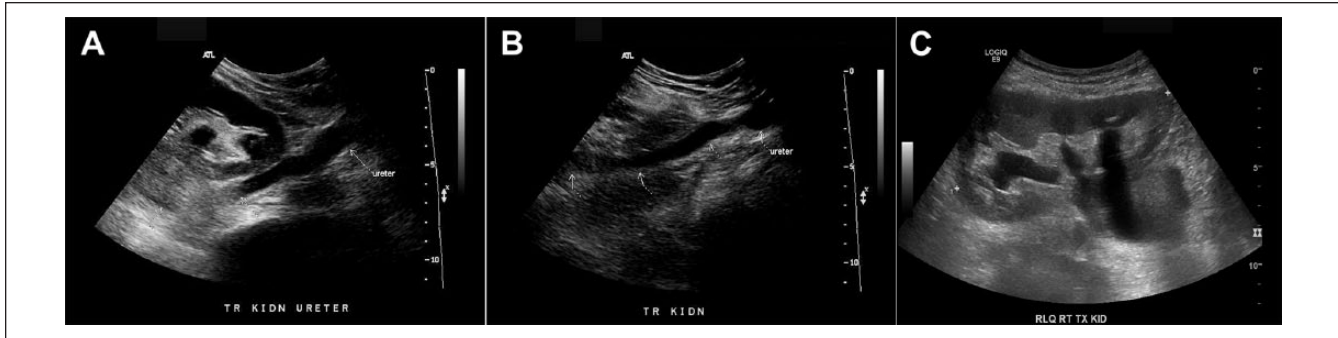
Ultrasound images of transplant kidney 1 week prior to admission, demonstrating mild hydronephrosis and incomplete visualization of distal ureter (A, B). Repeat ultrasound upon admission demonstrating interval worsening of hydronephrosis (C).
